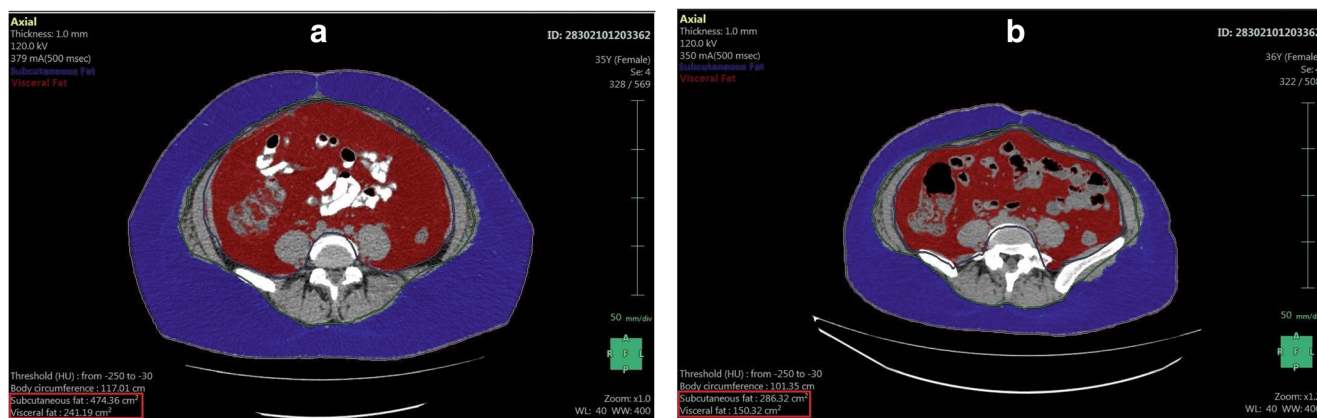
Abdominal CT axial view (2D) in a laparoscopic OAGB patient: (a) before operation; (b) 6 months after operation
